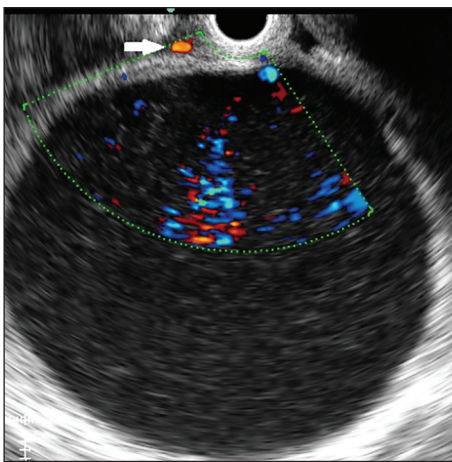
Endoscopic ultrasound evaluation of pseudocyst prior to drainage. A vessel is noted at the intended site of puncture on color Doppler (arrow)
